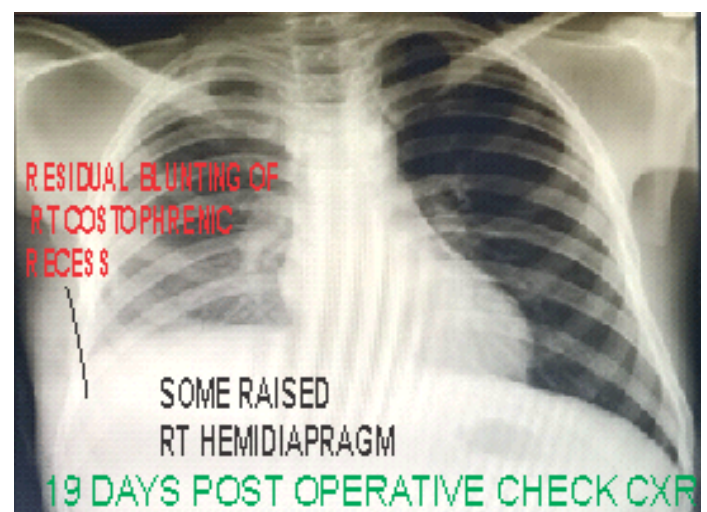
Postoperative chest radiograph obtained on postoperative day 19 showing satisfactory right lung expansion with residual blunting of the right costophrenic angle and mild elevation of the right hemidiaphragm.
